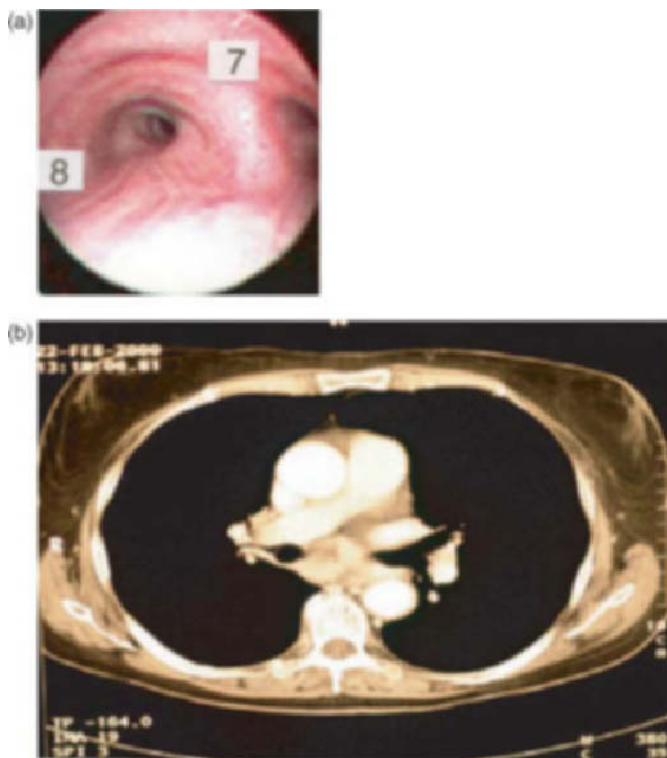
(a) Second bronchoscopic level visualizing stations 7 and 8 (right upper hilar and subcarina). (b) Computed tomography scan of subcarinal adenopathy.
